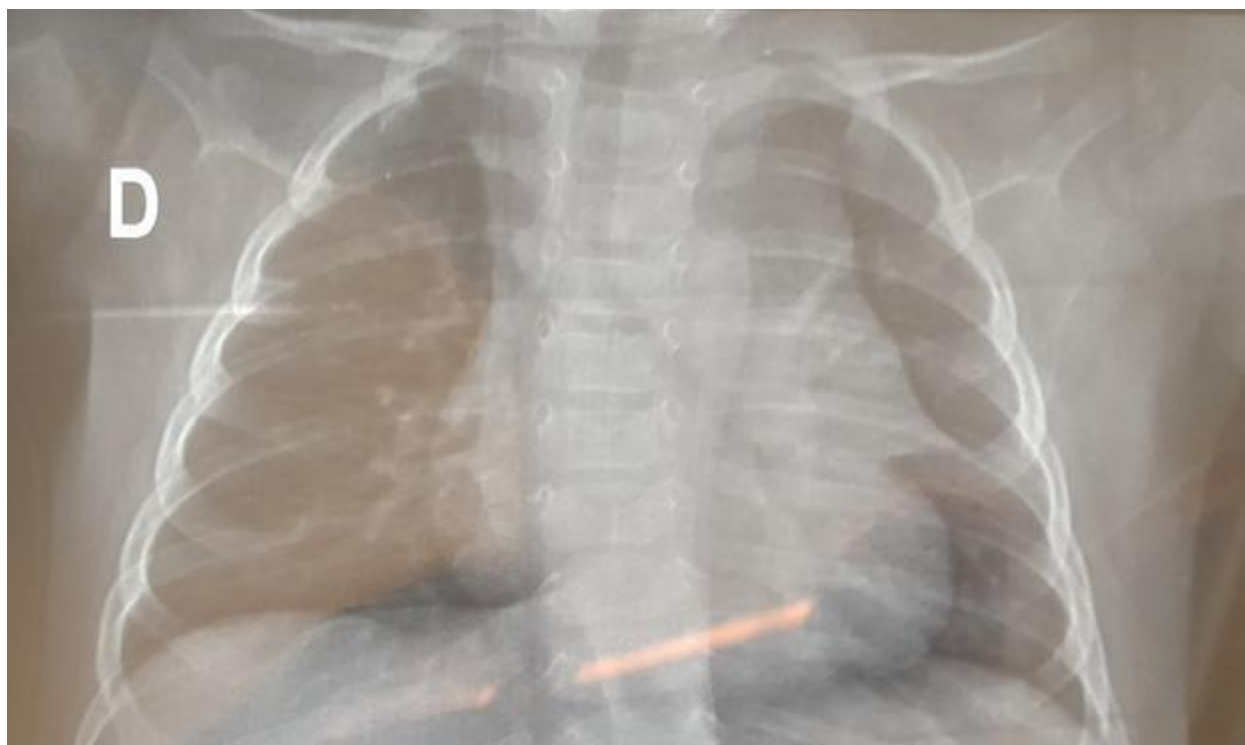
Preoperative chest X-ray in the infant with spinal muscular atrophy type 1
